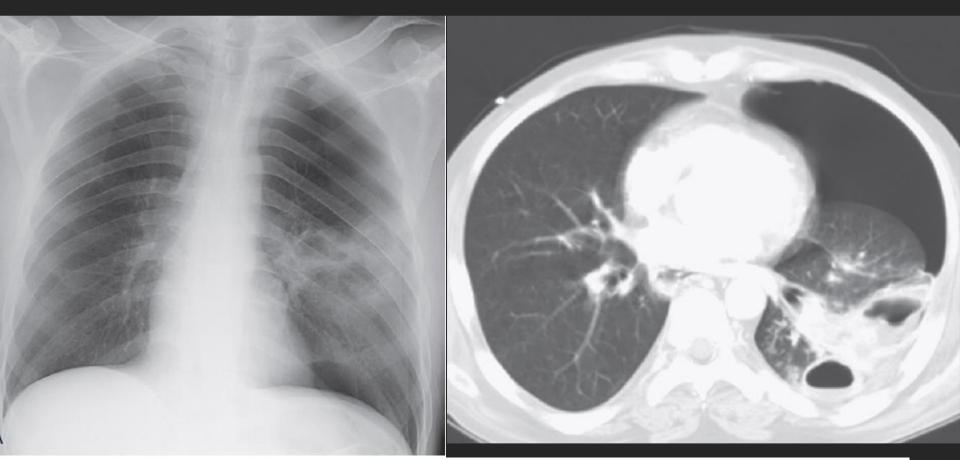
A, Localized area of air-space consolidation with multiple, eccentric lucencies and left pneumothorax in this patient with elevated WBC count and productive sputum is most suggestive of a necrotizing pneumonia. B, Computed tomography (CT) confirms consolidation with multiple cavities and a large pneumothorax. This is a gram-negative pneumonia, which is complicated by cavitation with bronchopleural fistula.
